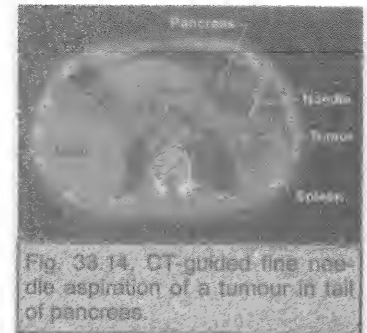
CT-guided fine needle aspiration of a tumour in tail of pancreas.
